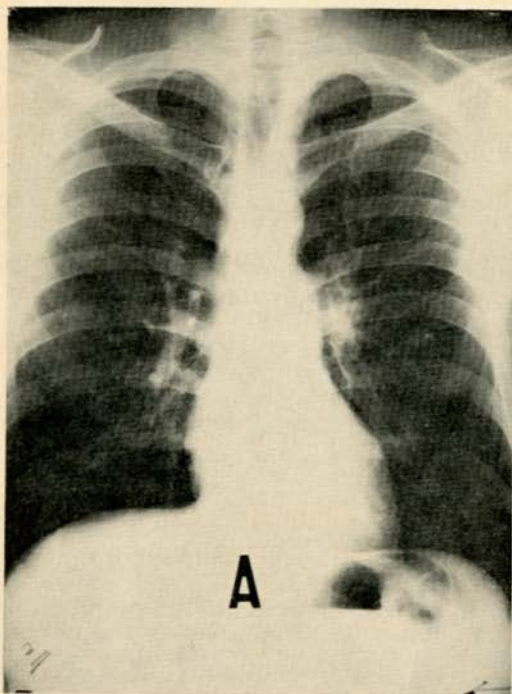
P.A. Chest X-ray 9 months later with disappearance of the nodularity.
